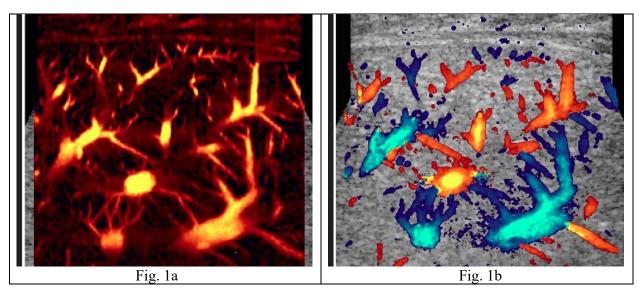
Power Doppler (left: 1a) and color Doppler image (right: 1b) of the superficial 3 cm below the hepatic capsule of the liver of a healthy volunteer. The resolution of the smallest vessel is approximately 200 microns on the left and 500 microns on the right. Color Doppler (1b) displays the magnitude of blood flow velocity along the up direction (red) and down direction (blue) of the vascular network.
